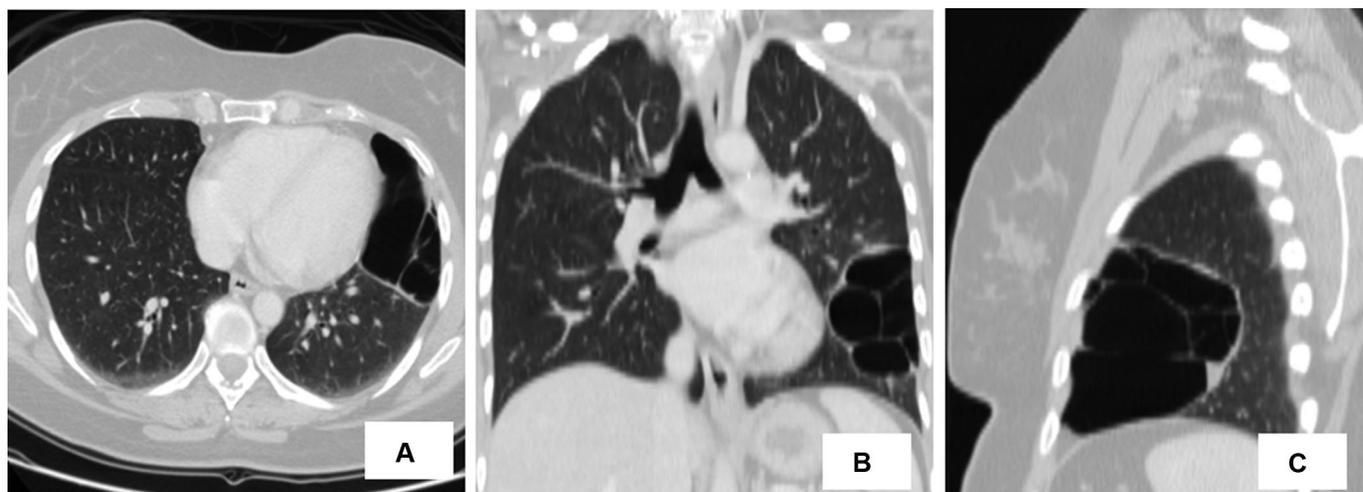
Axial computed tomography (A) image and postprocessed reconstructed coronal (B) and sagittal (C) views of the lungs confirmed the presence of a 98-mm multiseptated cystic lesion arising from the lingula, characterized by well-defined walls and thin intralesional septa. Other findings were unremarkable.
